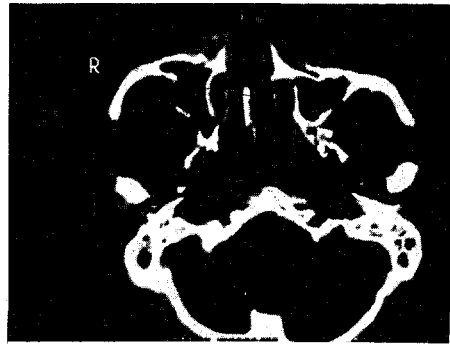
Preoperative maxilla computed tomogram.
